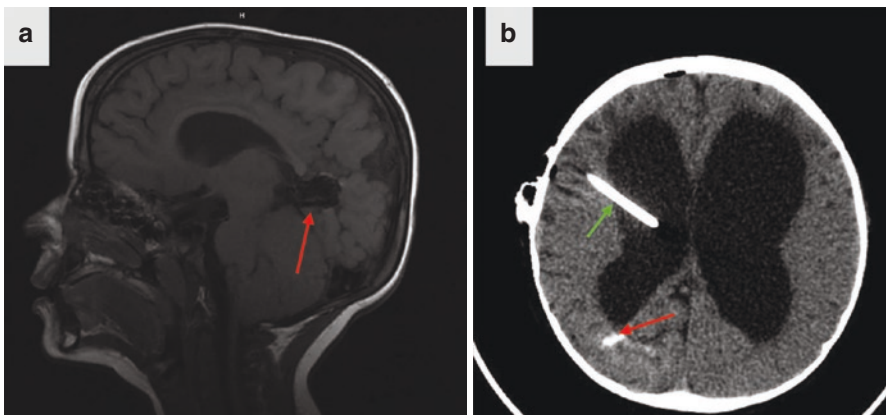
(a) Red arrow shows a vein of Galen malformation on a sagittal sequence an MRI image. (b) This is the same patient's CT scan almost 1 year later who went on to develop hydrocephalus due to the vein of Galen malformation. The red arrow shows a coil that was used to treat the malformation. The green arrow shows the VP shunt
